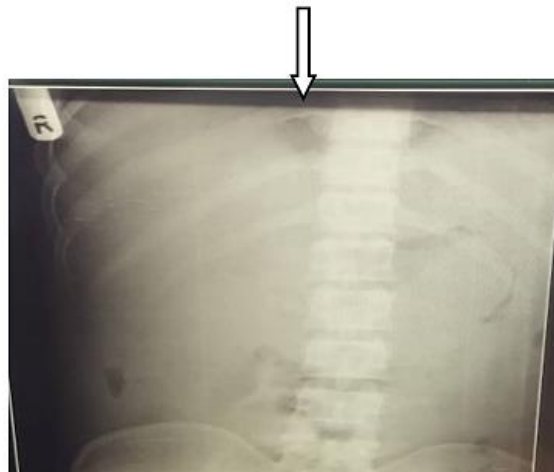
Plain abdominal X-ray showing minute bowel loops and generalized homogenous opacifications: indicator of presence of free fluid (white arrow)
